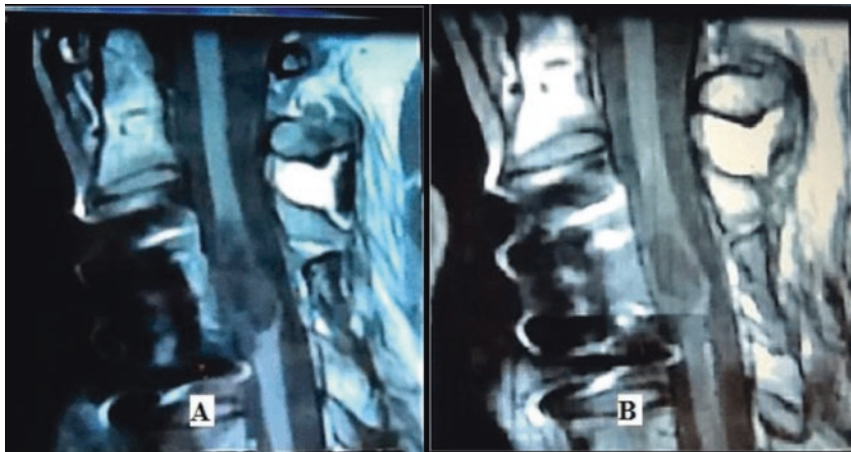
Tractographic images of a SCI patient before and after hESC therapy using magnetic resonance imaging (MRI)
